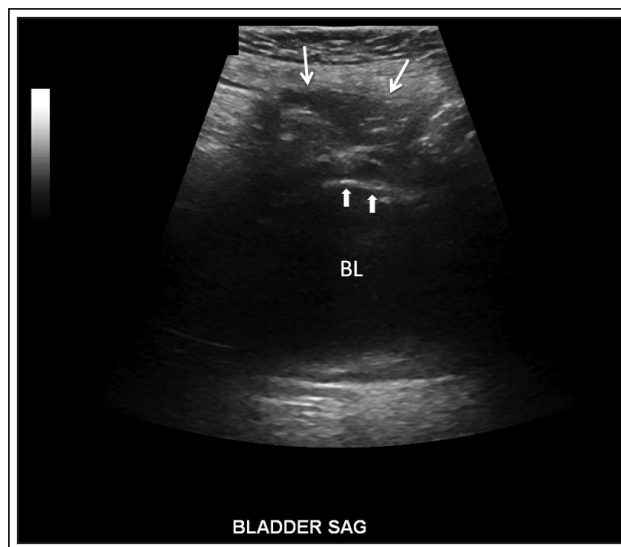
Ultrasound image (sagittal) showing intervening echogenic omental fat and bowel (thin arrows) between bladder wall (wide short arrows) and abdominal wall. BL = bladder lumen
